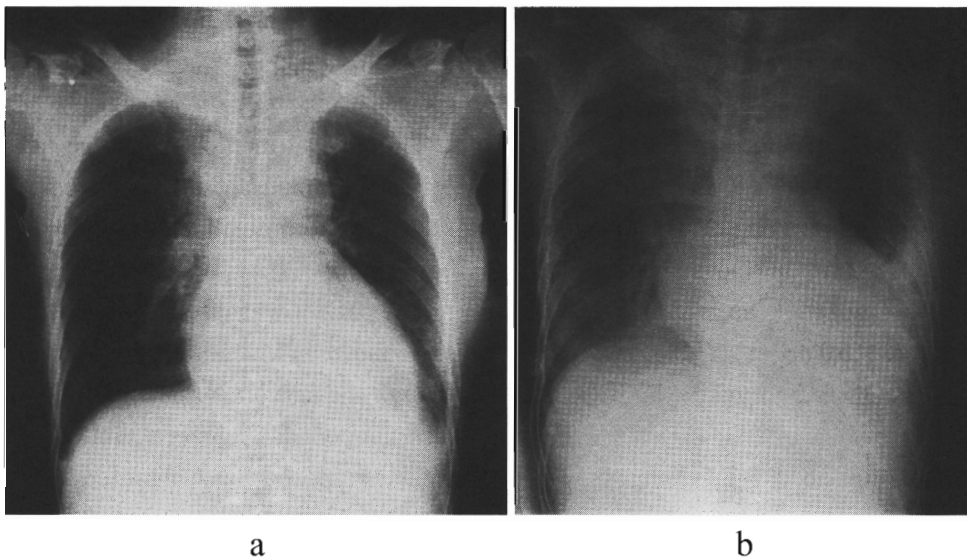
Chest radiography
